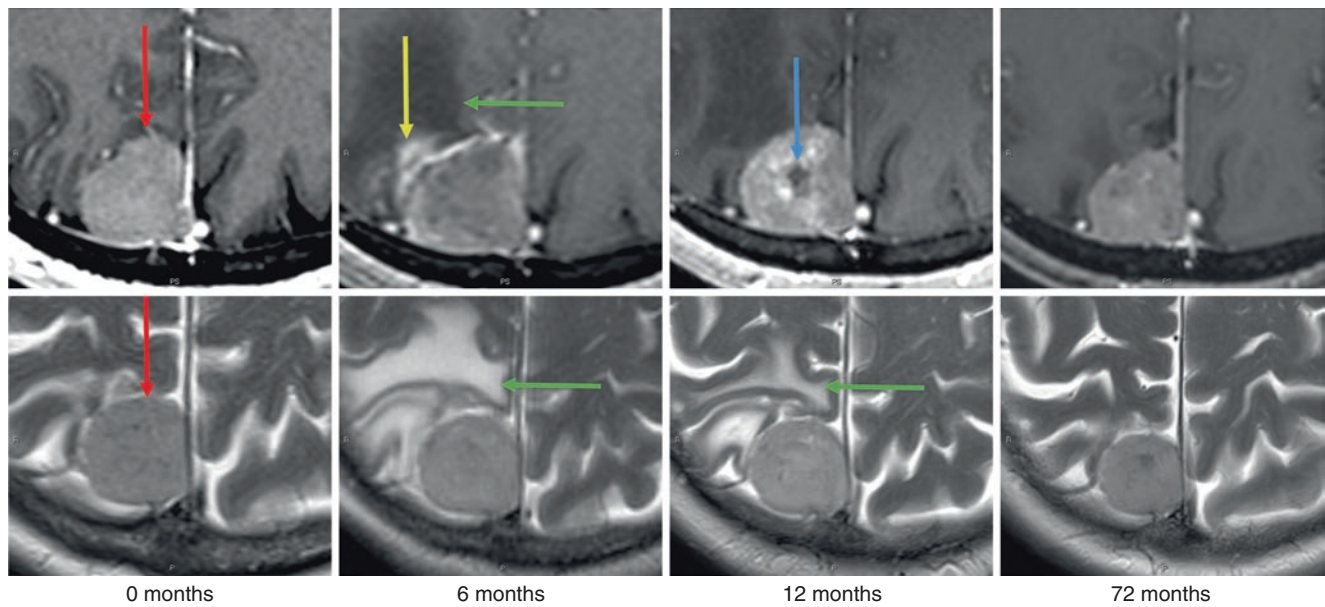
Meningioma. Axial post-contrast T1-weighted (top row) and axial T2-weighted (bottom row) MR imaging obtained at 0, 6, 12, and 72 months. Baseline pretreatment examination at 0 months demonstrates features typical of a meningioma (red arrows), with homogeneous enhancement and broad dural attachment; note the lack of perilesional edema present on T2-weighted images at 0 months. At 6 months, there is new perilesional edema shown as low signal on T1 and high signal on T2-weighted images (green arrows). Radiation-induced inflammatory leukoencephalopathy is seen as peritumoral
